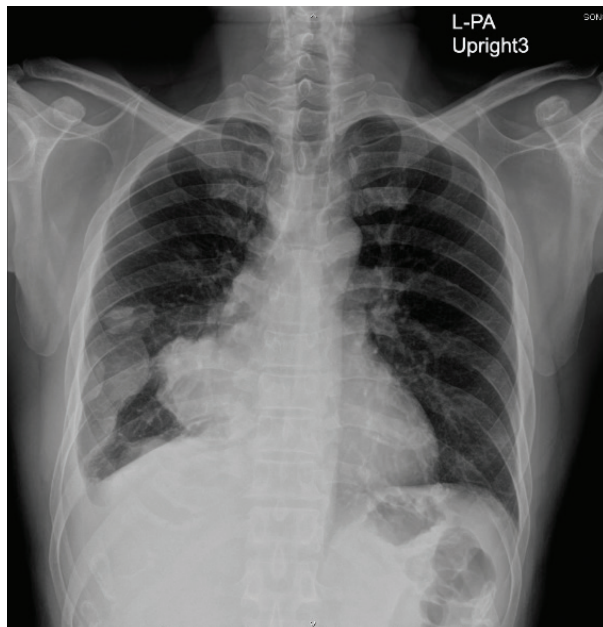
The initial chest radiograph reveals an anterior mediastinal mass and an adjacent pleural mass in the lower part of the right hemithorax.
